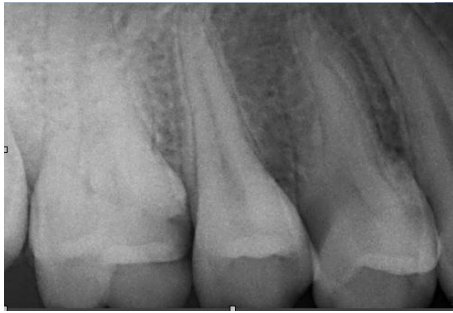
preoperative radiograph showing the right maxillary first molar had a deep carious lesion.
